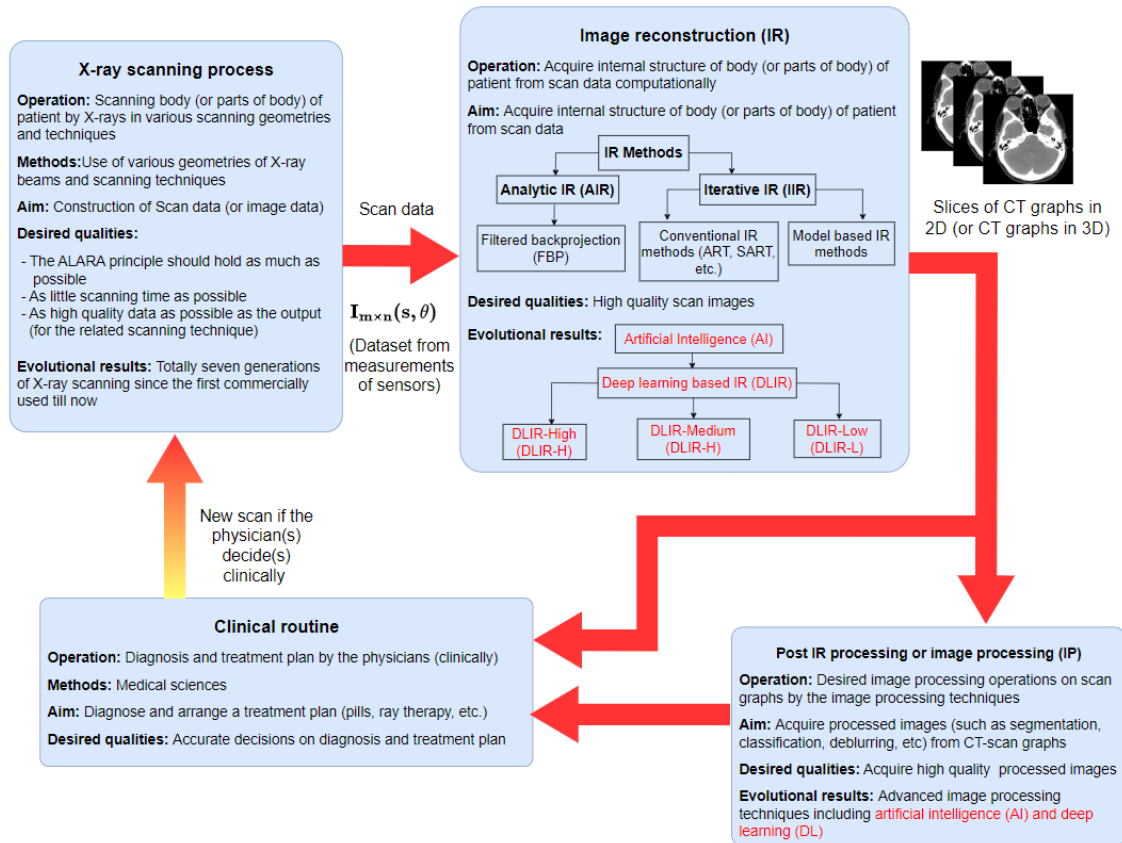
Steps of medical applications of modern X-ray computed tomography
